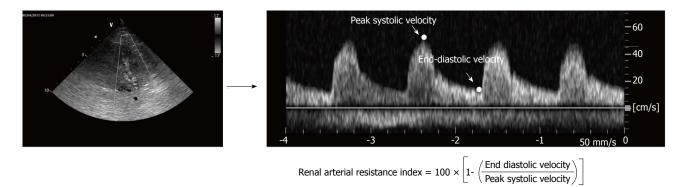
Calculation of Renal arterial Resistance Index. Renal arterial Doppler was performed using a 4 MHz probe, with the patient in the sitting position and using a posterior approach to visualise the kidney. The course of the right or left kidney segmental arteries is visualised by color Doppler flow and, at the middle tract level of the best one visualised, pulsed Doppler is performed. Peak systolic velocity and end diastolic velocity are used to calculate the renal arterial resistance index according to Pourcelot's formula.
